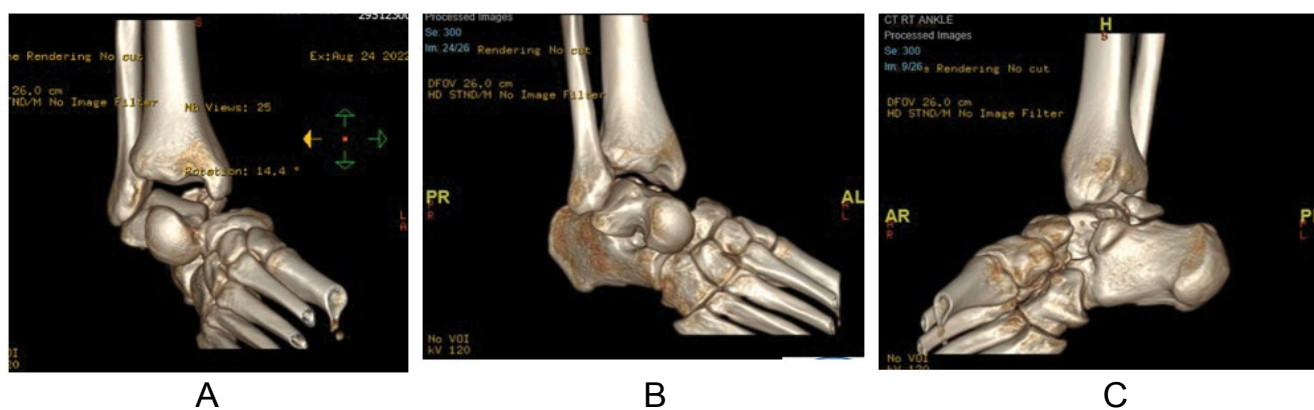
(a, b, c) 3D reconstructed CT images of the right ankle delineating the fracture morphology.
